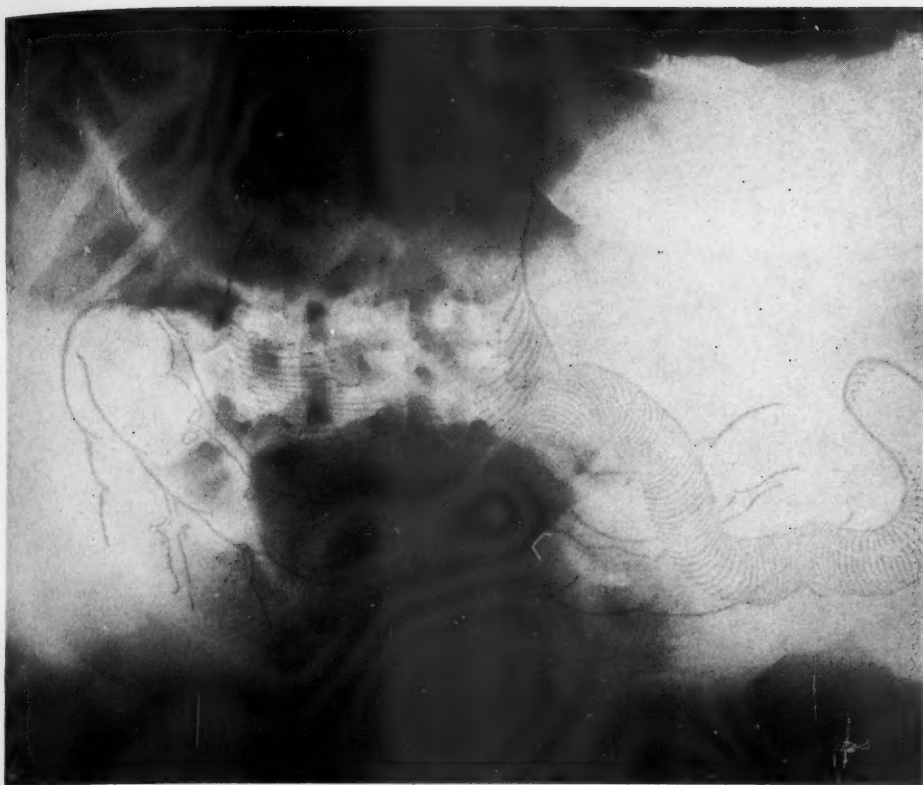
Roentgenogram showing superimposed acute intestinal obstruction while patient was awaiting surgery for the fistula.
